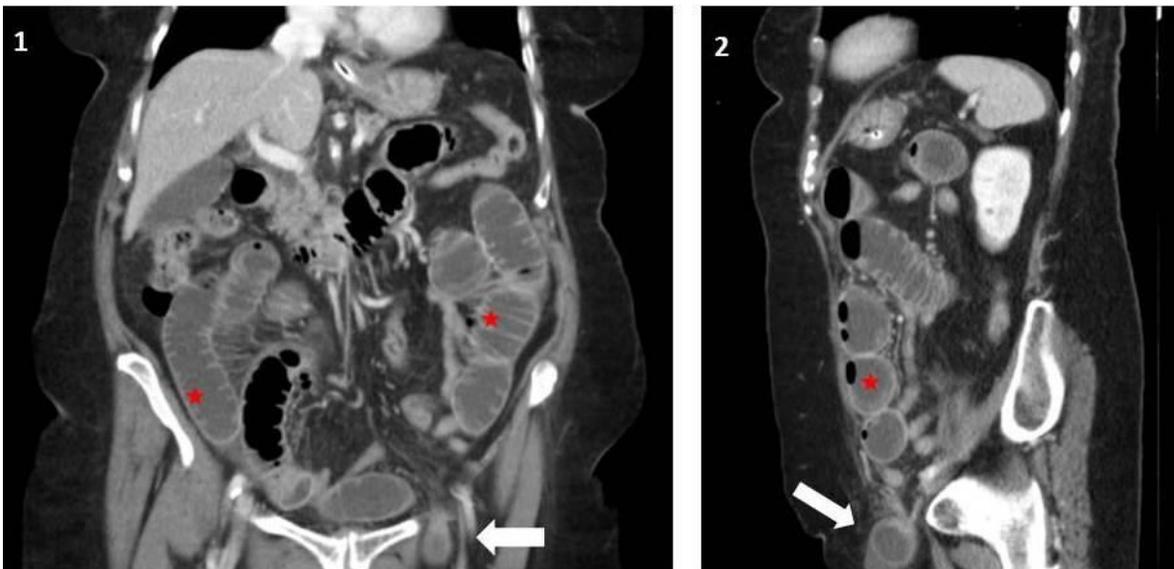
Enhanced CT shows dilated small bowel loops (red arrow) with a nodular soft tissue implant (white arrow) in a patient with peritoneal carcinomatosis from rectal cancer.
